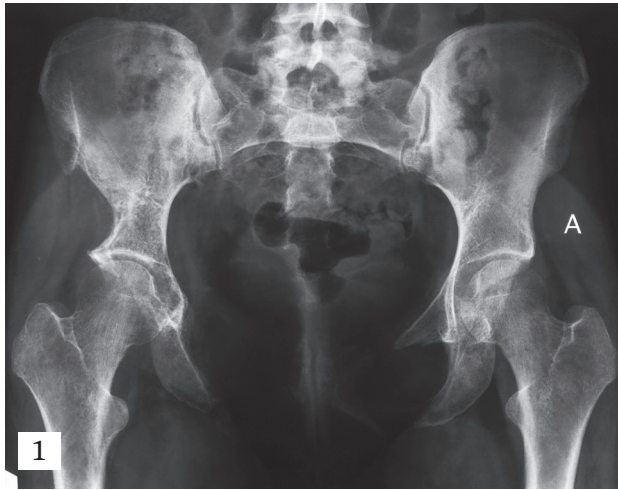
Plain AP radiograph of the pelvis
